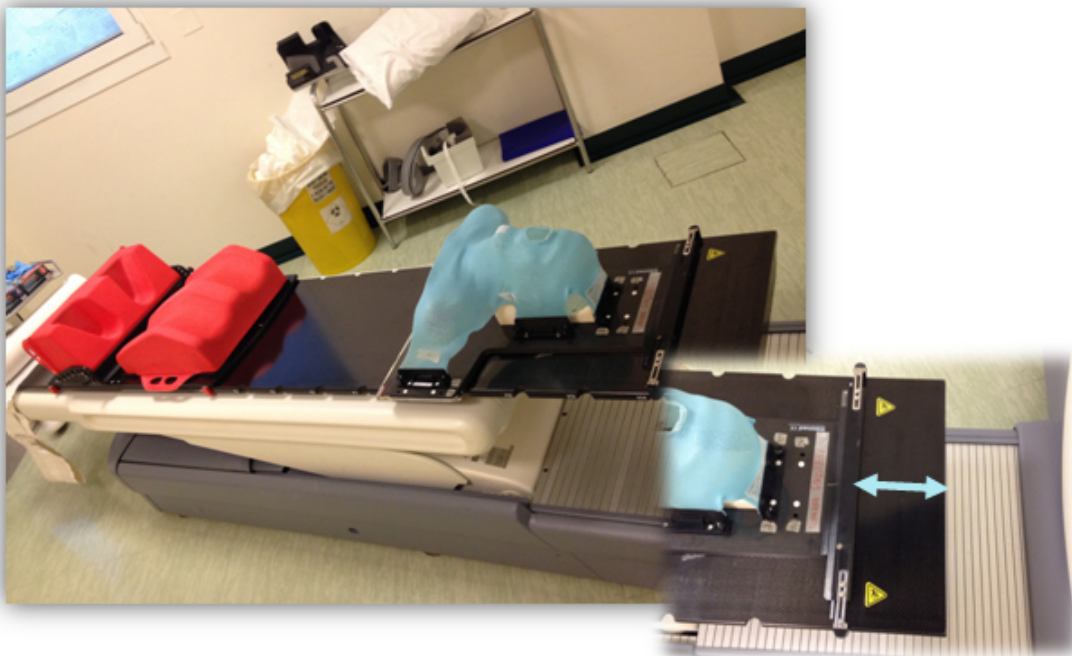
Pictures taken at the Nuclear Medicine Department of the Sant’Orsola-Malpighi Polyclinic, when the PET/CT scanner was being prepared for a treatment planning examination, where the patient was going to be immobilized with a mask and the Combifix. The blue arrow identifies the distance that cannot be utilized because of where the base plate insertion is located.
